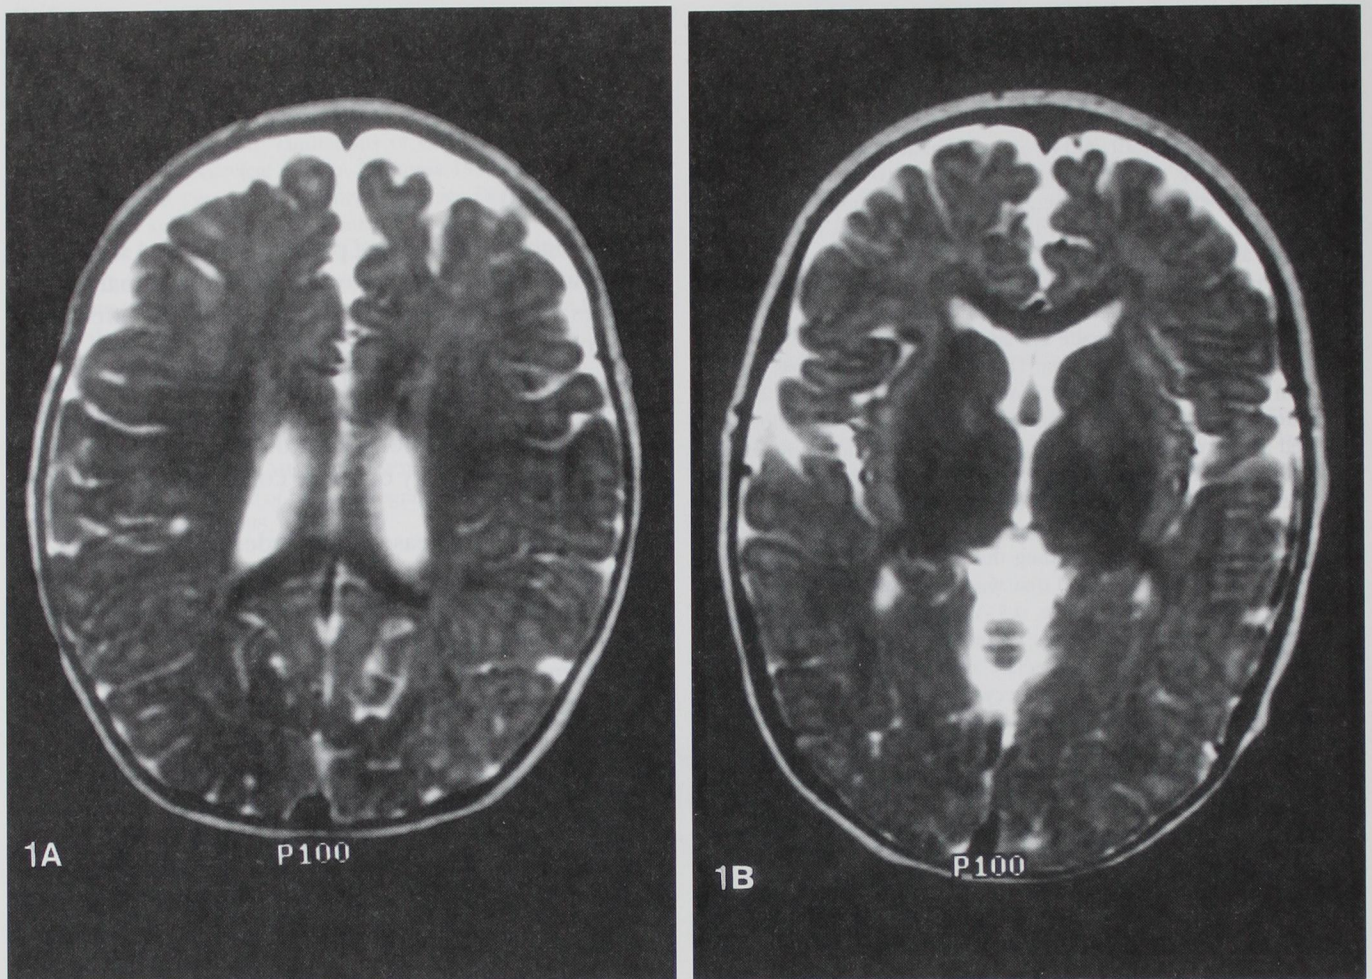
Magnetic resonance image scans of the brain, before and after cholecystectomy. *A* and *B* show two representative regions of the brain taken when the patient was aged 10 months. There is overall normal myelination and white matter intensity except for minimally increased signal in the basal ganglia. The ventricles are increased in size for the patient's age.
